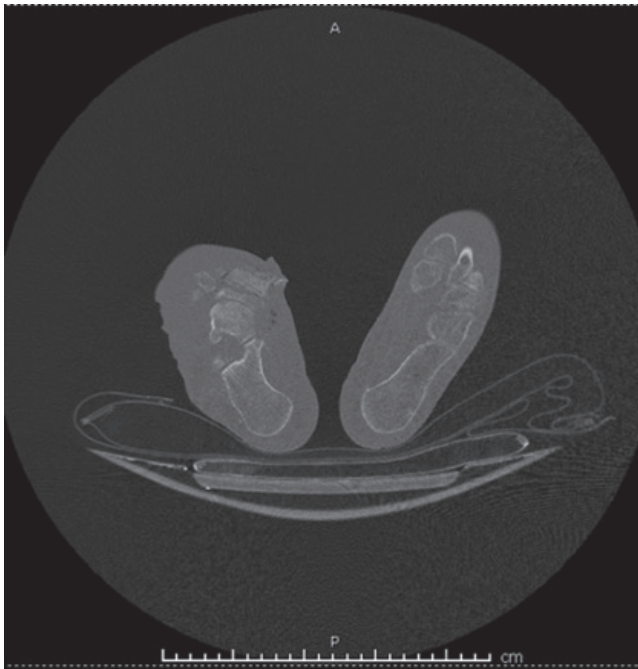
Non-contrast lower extremity CT was consistent with Charcot foot, diffuse soft tissue infection, osteomyelitis. It was not evaluated in favor of necrotizing fasciitis, emergency surgery was not considered.
